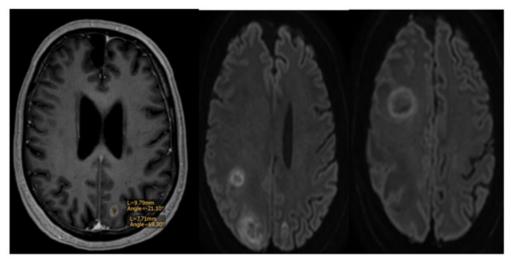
The initial magnetic resonance imaging of the skull (T1 weighted), where three small ring enhancing lesions were found subcortically. b. Two months later the magnetic resonance imaging showed multiple large-volume brain tumors.
